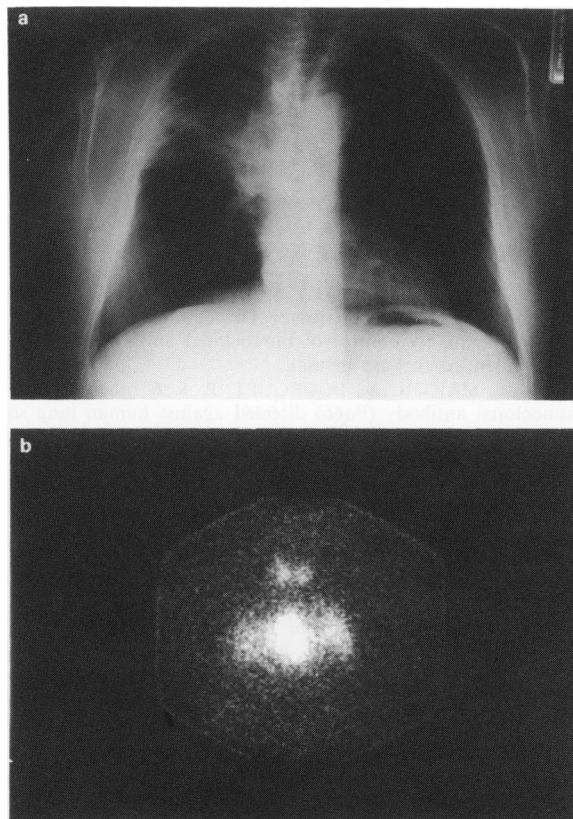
Patient no. 8. a, Chest X-ray. Lung carcinoma radiologically limited to the right upper lobe. b, IS, anterior view, showing an intense uptake of the monoclonal antibody in the mediastinum and a diffuse uptake in the two lung fields. Surgical control showed that the contralateral and mediastinal involvement corresponded to widespread small tumoral granulations.
